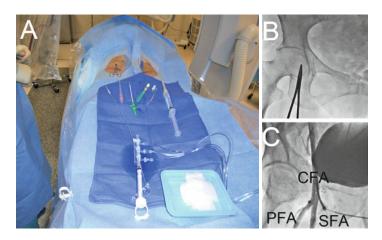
Femoral arterial access. Both groins are prepared and the equipment is ready (a), with arterial forceps in place to locate the optimal puncture site by x-ray (b). Angiography (c) reveals that the sheath is in the common femoral artery (CFA), above the bifurcation into the superficial femoral artery (SFA) and profunda femoris artery (PFA)
